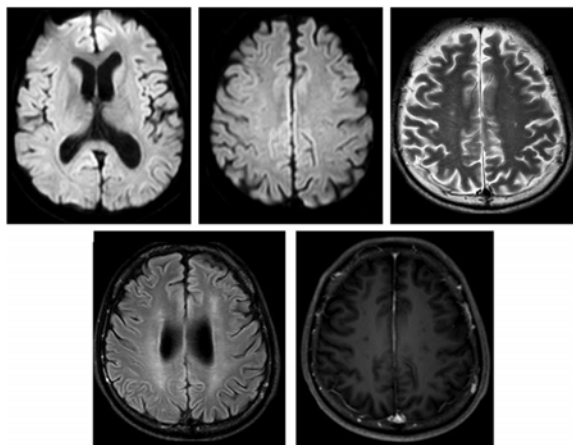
MRI brain on 4 months after the operation showed a transformation of previously seen multiple lacunar infarctions at bilateral frontal, parietal, periventricular region and centrum semiovale to be a nonspecific white matter change. There was focus brain atrophy at cerebral, cerebellar and brainstem area.
